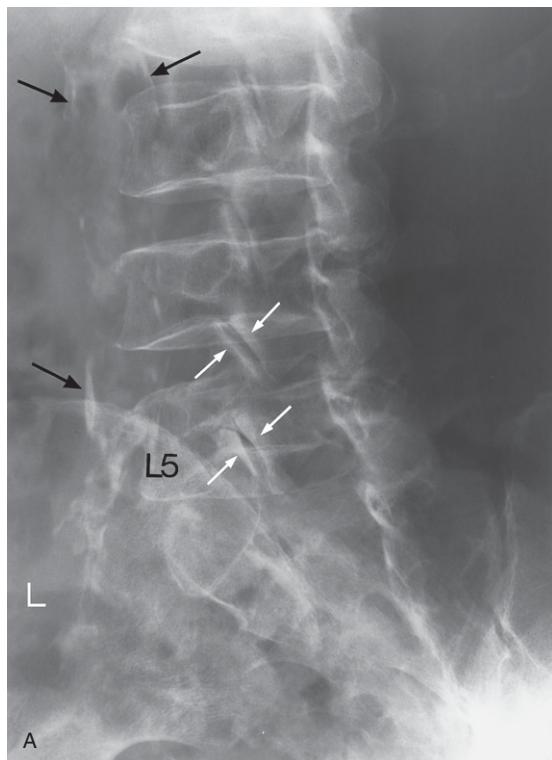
(A) Lumbar spine oblique plain X-ray image. L = left side of the patient. Note the osteoarthritic changes in the zygapophysial joints as indicated by subchondral sclerosis (white arrows). The patchy atheromatous plaques in the abdominal aorta are indicated with black arrows. L5 = fifth lumbar vertebra. (B) CT axial image showing the aorta (A), right kidney (K) and blood vessels leaving it, and the liver (L). Z = left zygapophysial (facet) joint; 1 = psoas major muscle; 2 = quadratus lumborum muscle; 3 = iliocostalis lumborum muscle; 4 = longissimus thoracis muscle; 5 = multifidus muscle.
